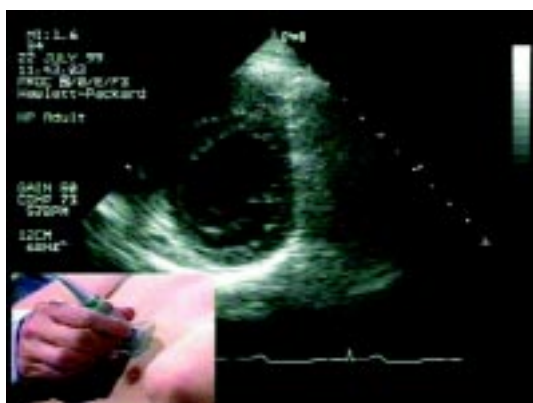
The position of the transducer required to obtain short axis cuts through the ventricles from the parasternal window.
